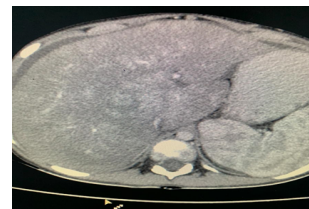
Venous Phase of Triphasic CT showing Marked Attenuation of veins in liver. Liver showing non enhancing areas with enlargement of caudate nucleus.
